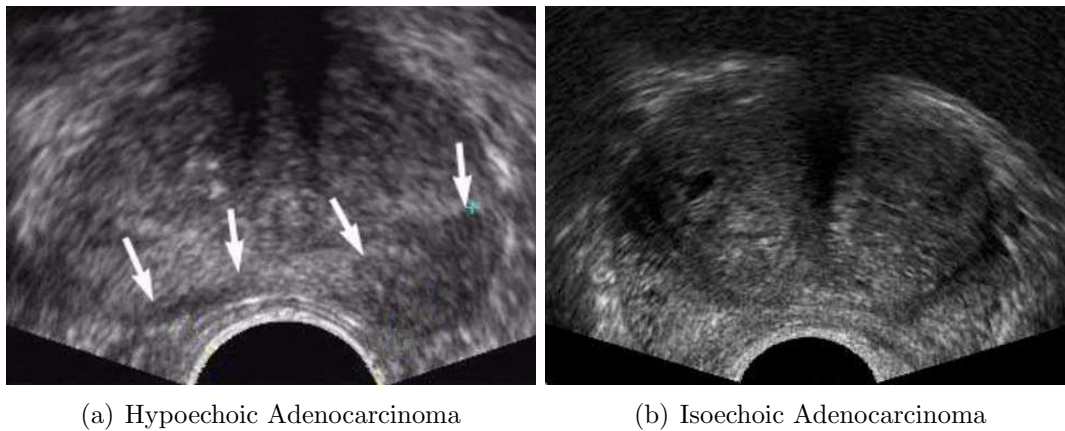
Ultrasonography of PCa (adenocarcinoma). (a) Axial TRUS scan shows a hypoechoic area in the left peripheral zone and a small hypoechoic area in right peripheral zone (arrows). Biopsy revealed an adenocarcinoma; (b) Axial TRUS scan in a patient with clinical benign prostatic hyperplasia. Enlargement of the transition zone is present, but no focal abnormality is observed in the peripheral zone. A systematic, 6-core biopsy revealed adenocarcinoma from both lobes of the prostate (i.e. this is an isoechoic tumor in the peripheral zone of both prostatic lobes). Copyright © 1994-2012 by WebMD LLC.
